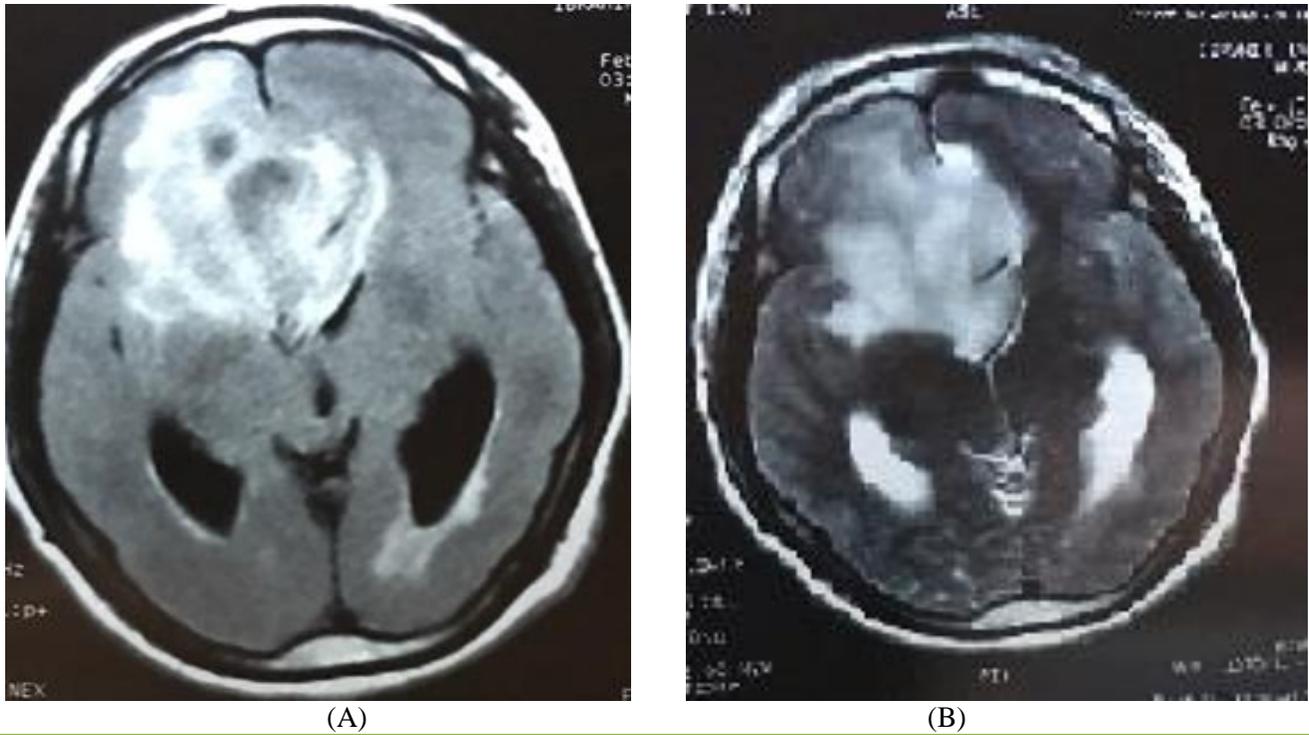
MRI with contrast shows large intra axial frontal lobe GBM recurrent lesion involved the genu, body of corpus callosum with obstructive changes.
